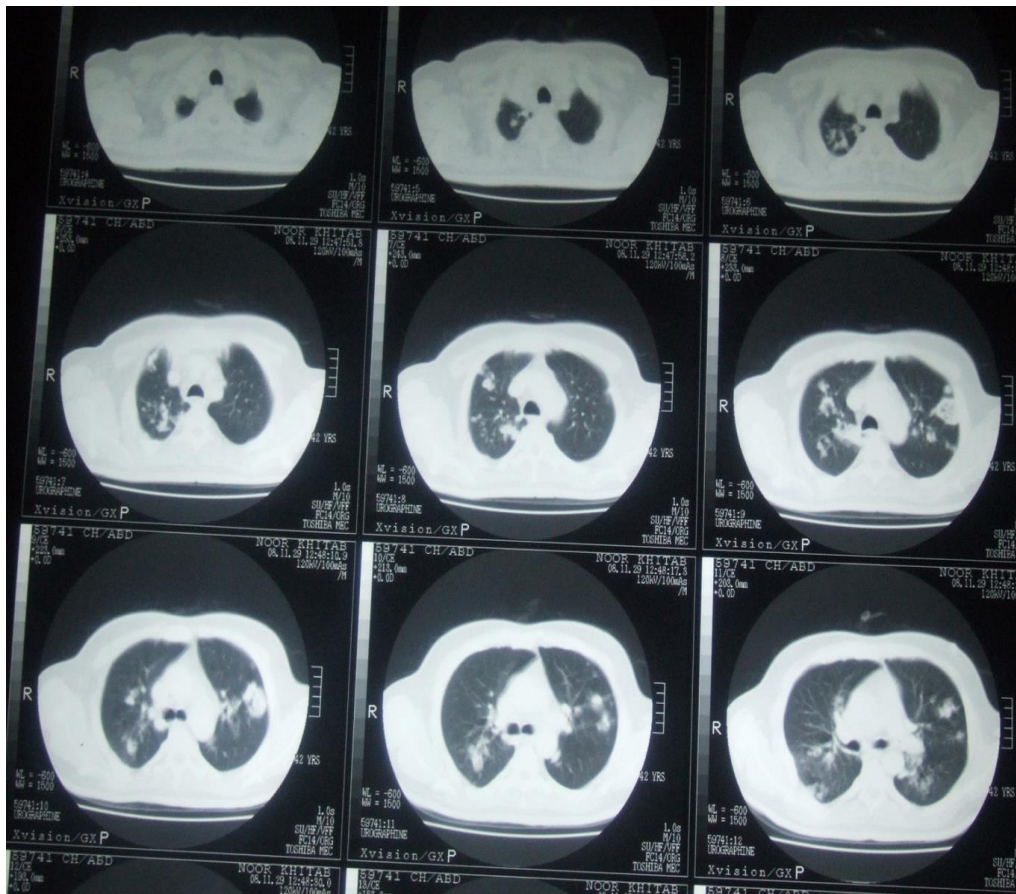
CT THORAX (Lung window), showing Bilateral Pulmonary nodules some are cavitory, consolidations and alveolar infiltrates are seen bilaterally and there are fractures of ribs on right side due to secondary to fall of the patient few months back. It is not pathological fractures.
